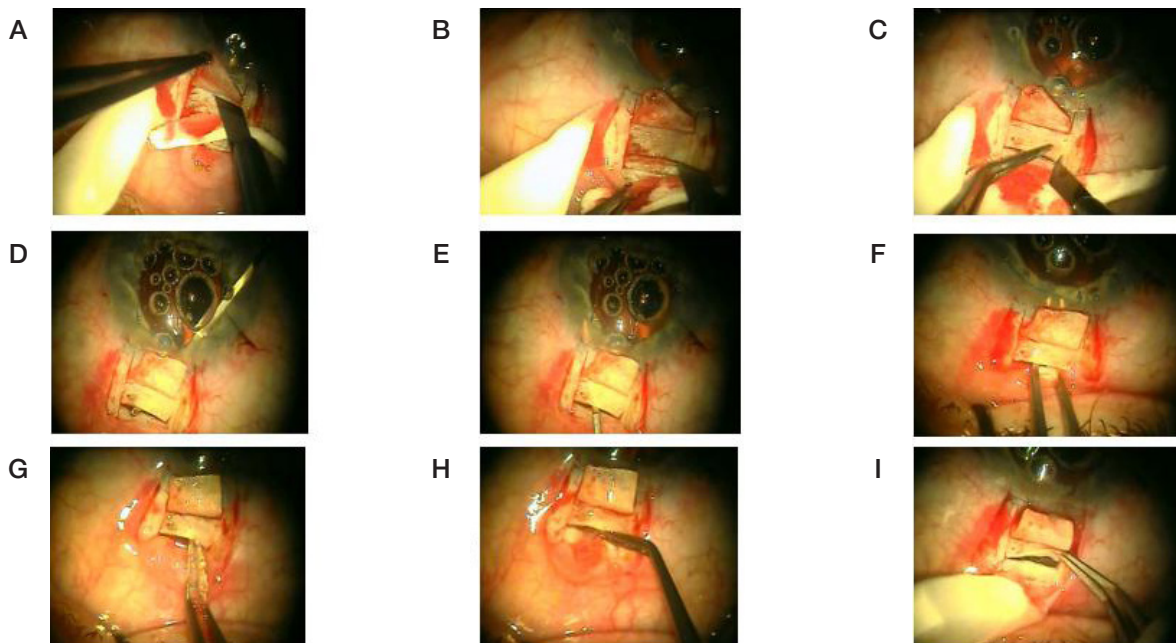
A. Dissection of limbal based superficial scleral flap (3×2 mm). B. Horizontal incision of the sclera's deep layers up to the ciliary body. C. Formation of the valve by making 2 vertical incisions 1.0 mm long at both ends of the incision. D. Cyclodialysis *ab interno* step. Using a spatula inserted into AC through the paracentesis the ciliary body was separated from the scleral spur, spatula's distal end exiting through the incision in the sclera. E. Completion of tunnel formation *ab externo*. The spatula was inserted through the scleral incision, its end entered the AC; the ciliary body was detached from sclera along the entire length of the incision. F. CT expansion with the help of suture tying forceps. G. NACI implantation into the supraciliary space. Pre-moistened in the balanced salt solution NACI was captured between tying platforms of the forceps and was inserted into the tunnel through the incision in the sclera and was pushed forward till it appeared in the AC angle. H. NACI implantation in the suprachoroidal space. Posterior end of the implant was captured with toothed forceps and inserted under the back lip of the scleral incision into the suprachoroidal space. I. NACI position checkup
